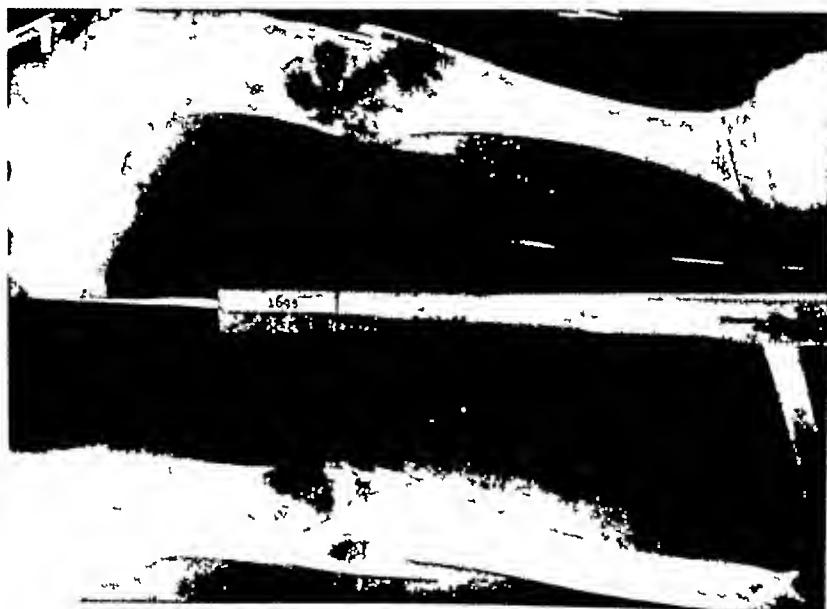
Roentgenogram taken on April 1, 1935, shows a pathologic fracture of the right humerus near the middle. Multilocular cystic lesions involving the proximal half of the humerus may be seen. There were no changes in the epiphysis.
